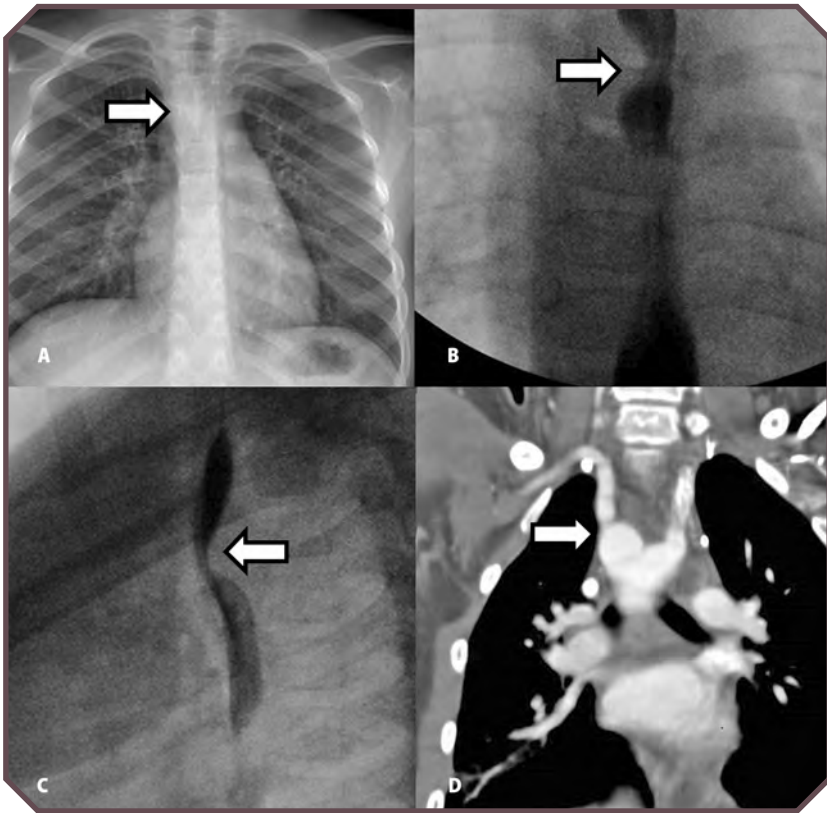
Vascular ring in a 4-year-old boy. A. Frontal chest radiograph shows mass effect on the right side of the trachea, suggesting a vascular ring (arrow). B. Frontal and C. lateral views from barium esophagography demonstrate mass effect on the esophagus at the level of the aortic arch (arrows). D. Coronal reformatted contrast-enhanced computed tomographic image confirms a right arch (arrow on D) with aberrant left subclavian artery.
